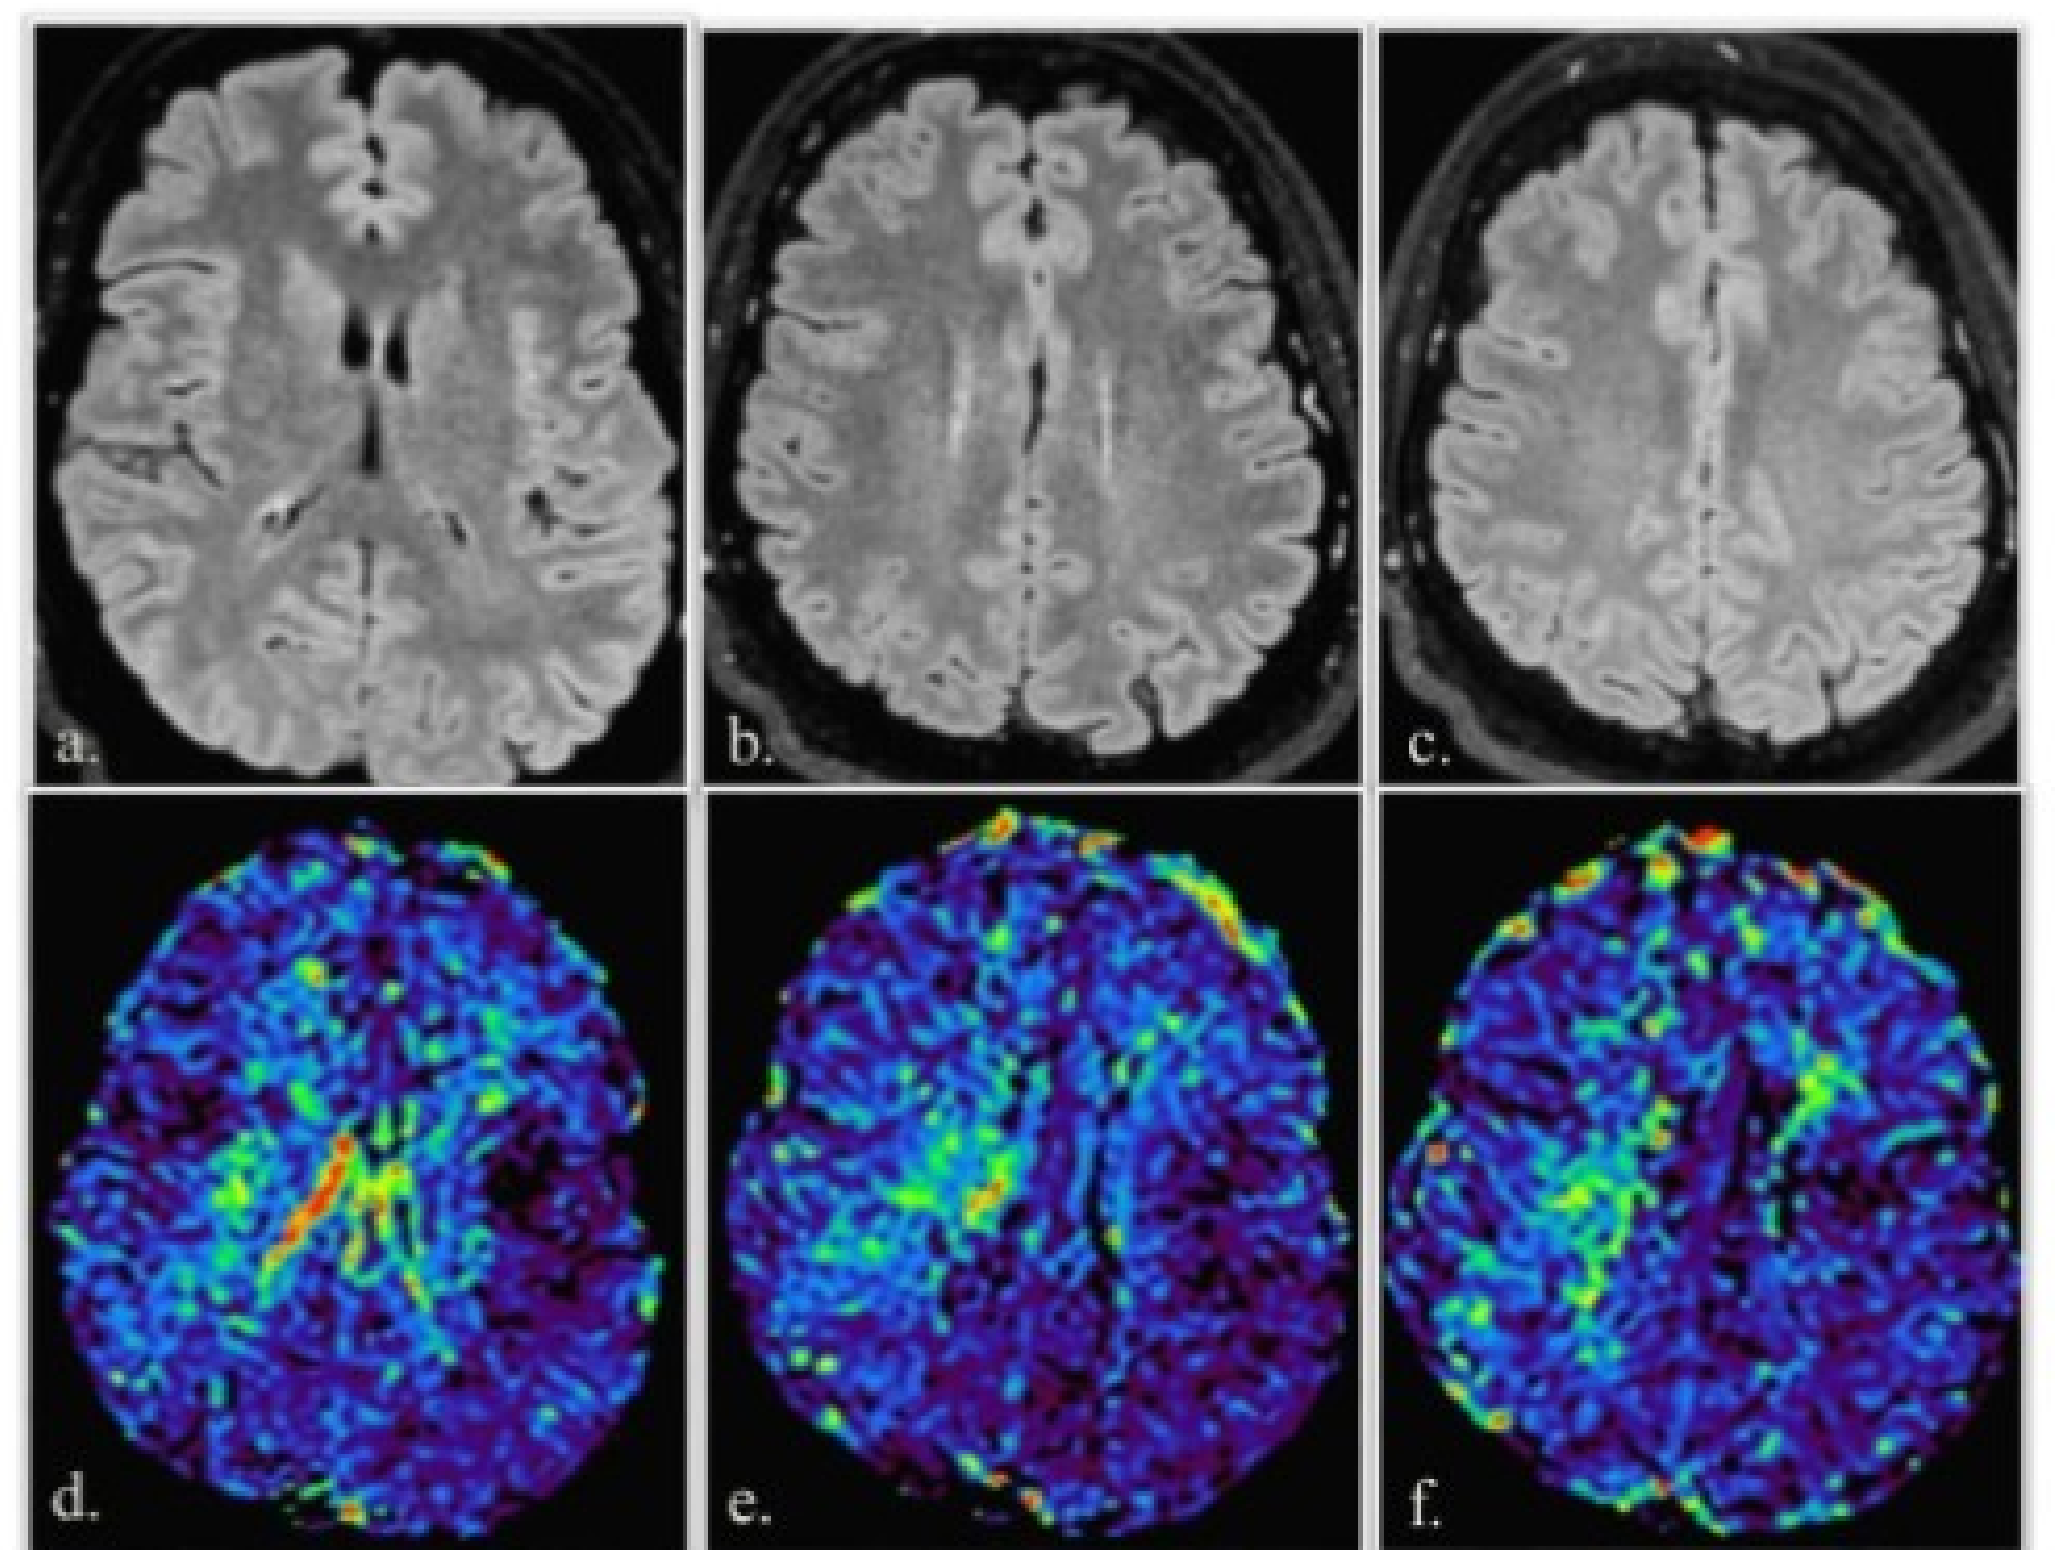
Axial Fluid-Attenuated Inversion Recovery (FLAIR) Magnetic Resonance Imaging [a-c]; Perfusion Dynamic Susceptibility Contrast (DSC) MRI with Mean Transit Time (MTT) map [d-f]
